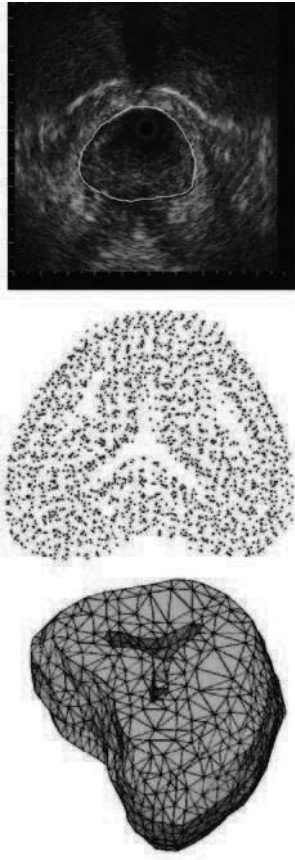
Adaptive model of the prostate volume. From top to bottom: a) Segmented ultrasound image. b) Morphological shape interpolation and adaptive sampling. c) Adaptive tetrahedral mesh.
